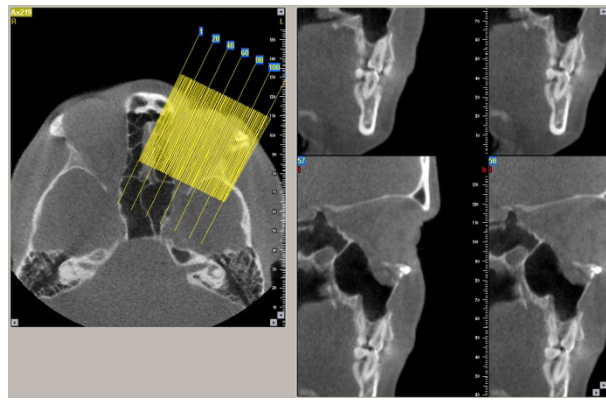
CBCT oblique sagittal extracted sections.
